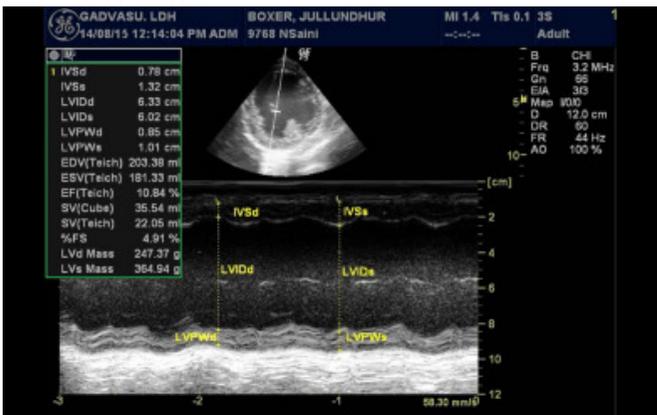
M mode echocardiography through right Para-sternal short axis view at the level of chordae-tendinae revealing dilation of left ventricle
